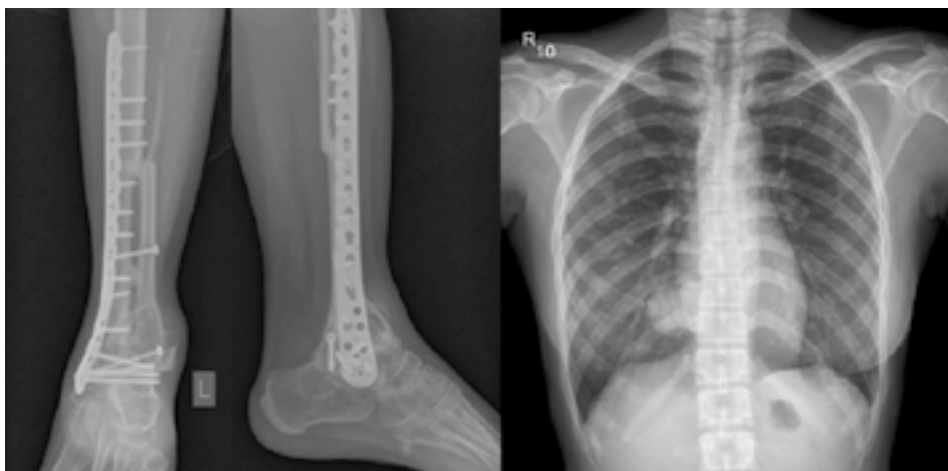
Chest and ankle X-rays taken 2 years after the first surgery, showing recurrence at the initial primary site with metastases to the lung despite receiving 6 months of bisphosphonate treatment
